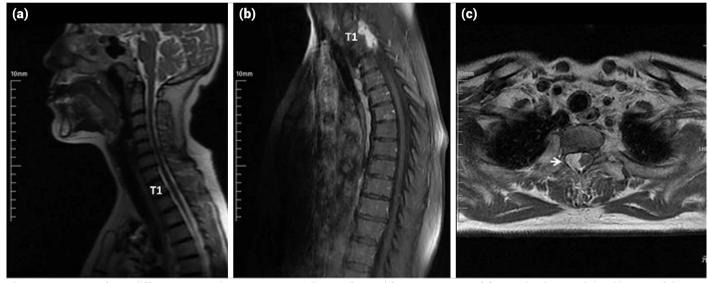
Images of two different magnetic resonance studies performed four years apart. (a) A sagittal T2-weighted image of the patient in 2014 showed no mass lesion. Postcontrast sagittal (b) and axial (c) T1-weighted images performed in 2018 revealed a mass lesion with contrast enhancement at the T1-2 levels occupying the right half of the spinal canal (white arrow).
